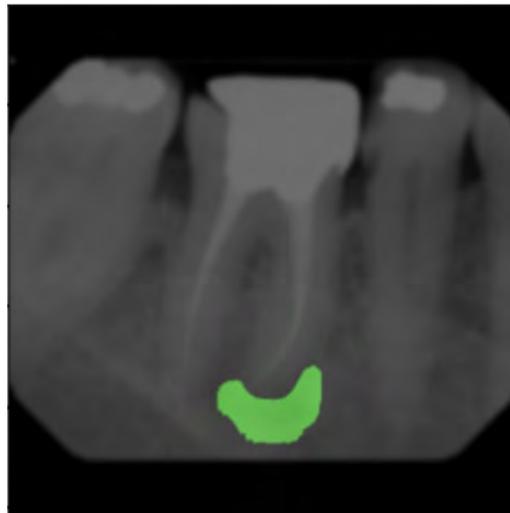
Image using AI Visualization to Identify the Periapical Radiolucency (PARL)
